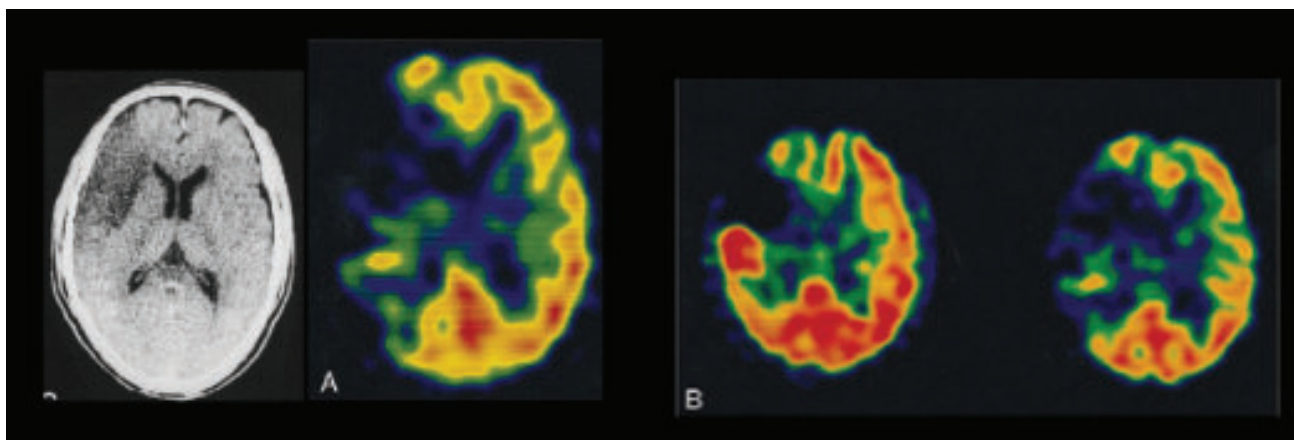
54-year-old man with atrial fibrillation and sudden onset of left-sided hemiparesis. Figure (A) CT scan of brain and 99mTc-HMPAO SPECT image 4.5 hours after the onset of stroke shows hypoactivity in the right frontal and temporal lobes. (B) 99mTc-HMPAO SPECT image (left) obtained 12 hours after the initial study shows hyperactivity in the right temporal lobe; a 99mTcECD SPECT image (right) shows hypoactivity in the same area.
